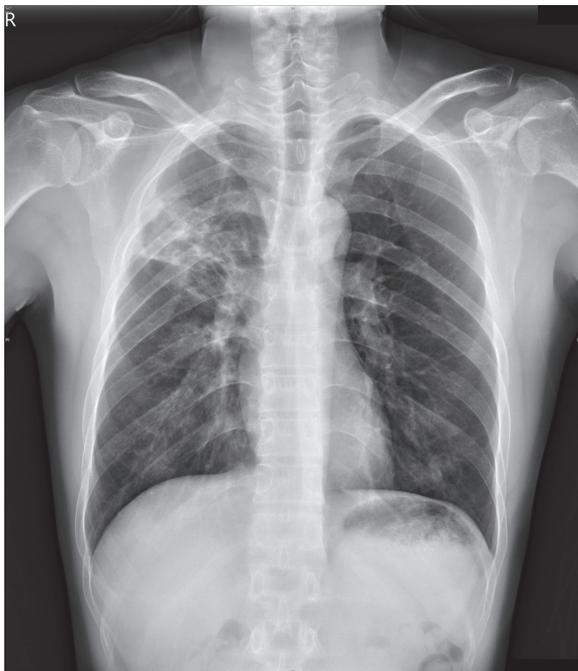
Chest radiography (CXR) showed a poorly defined opacity in the right upper lung. A soft tissue mass in a cavity can vaguely be seen.
